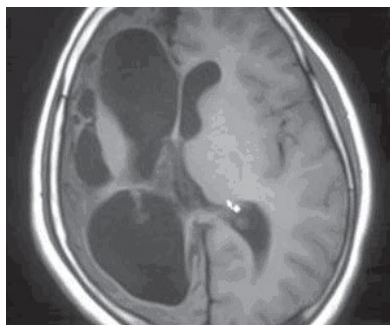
Magnetic Resonance Imaging of the brain (1.5 Tesla; T1 image) at 11years of age showing unilateral hydrocephalus-ex vacuo on the right side. On diffusion weighted MRI-images cause of brain volume loss was confirmed as ischemic atrophy. The fronto-parietal, temporo-occipital, telencephalic affected areas are supplied by middle cerebral artery.
